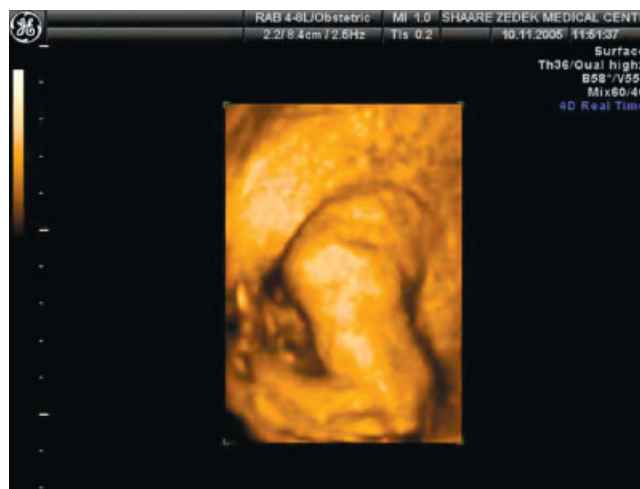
Three-dimensional ultrasound image of the fetal hand and arm outside the uterine cavity.
